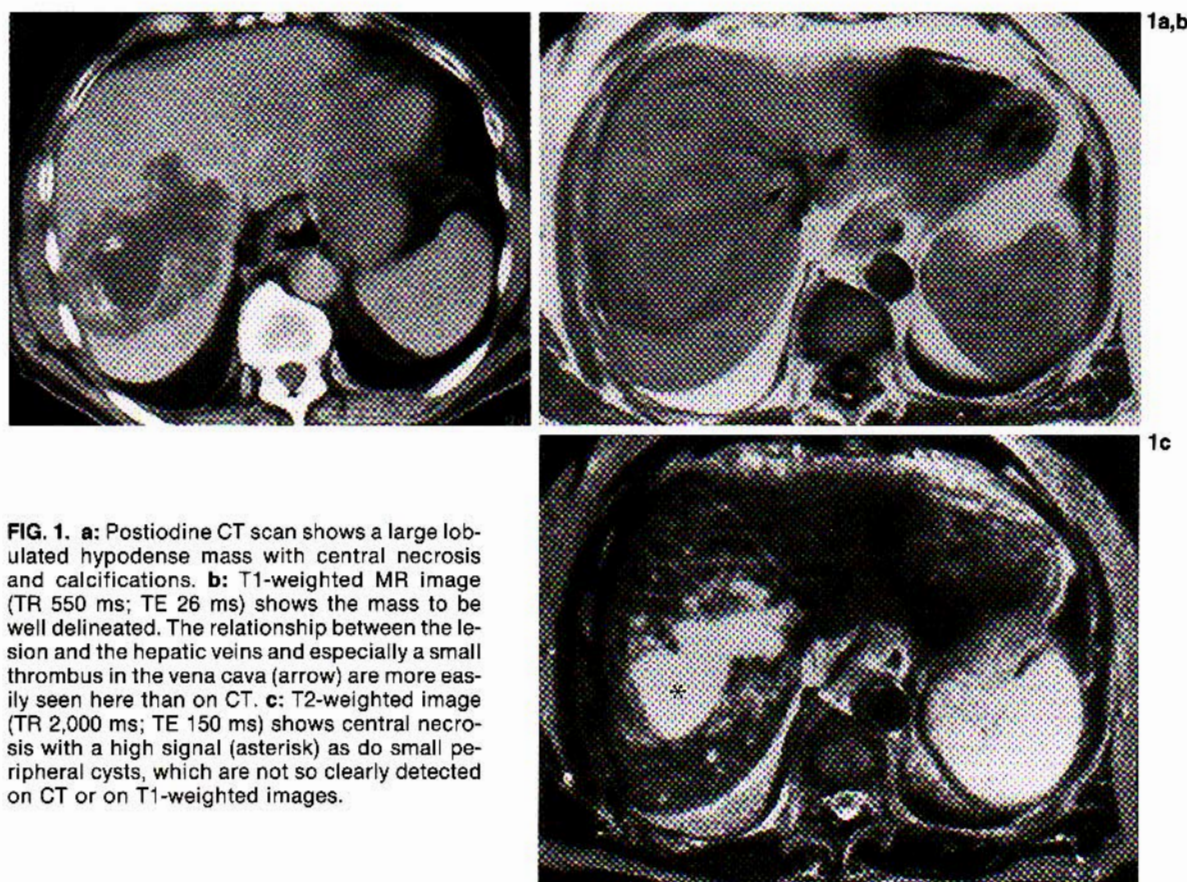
a: Postiodine CT scan shows a large lobulated hypodense mass with central necrosis and calcifications. b: T1-weighted MR image (TR 550 ms; TE 26 ms) shows the mass to be well delineated. The relationship between the lesion and the hepatic veins and especially a small thrombus in the vena cava (arrow) are more easily seen here than on CT. c: T2-weighted image (TR 2,000 ms; TE 150 ms) shows central necrosis with a high signal (asterisk) as do small peripheral cysts, which are not so clearly detected on CT or on T1-weighted images.
